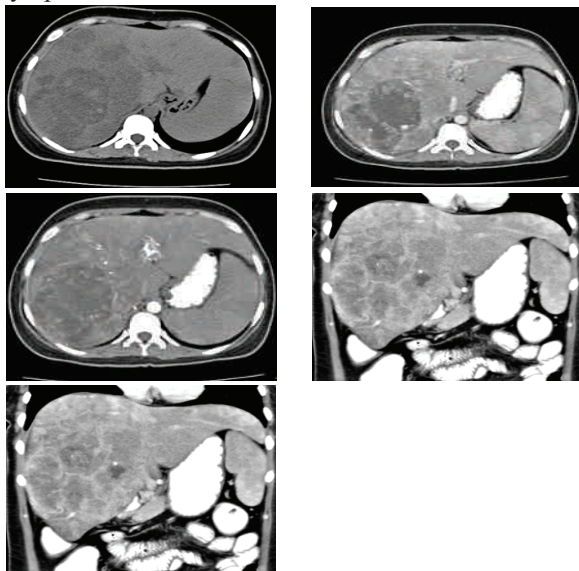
CT revealed heterogeneously enhancing predominantly cystic mass with septal enhancement
